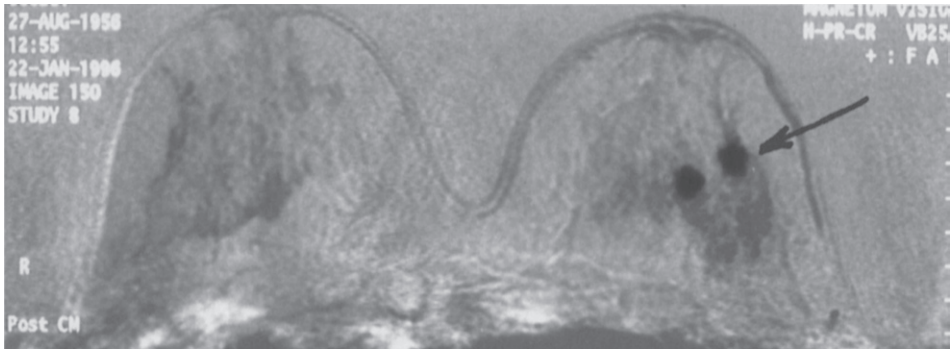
MRI subtraction image 5 minutes after intravenous contrast administration showing the enhancing double lesion in the left breast of patient D.
